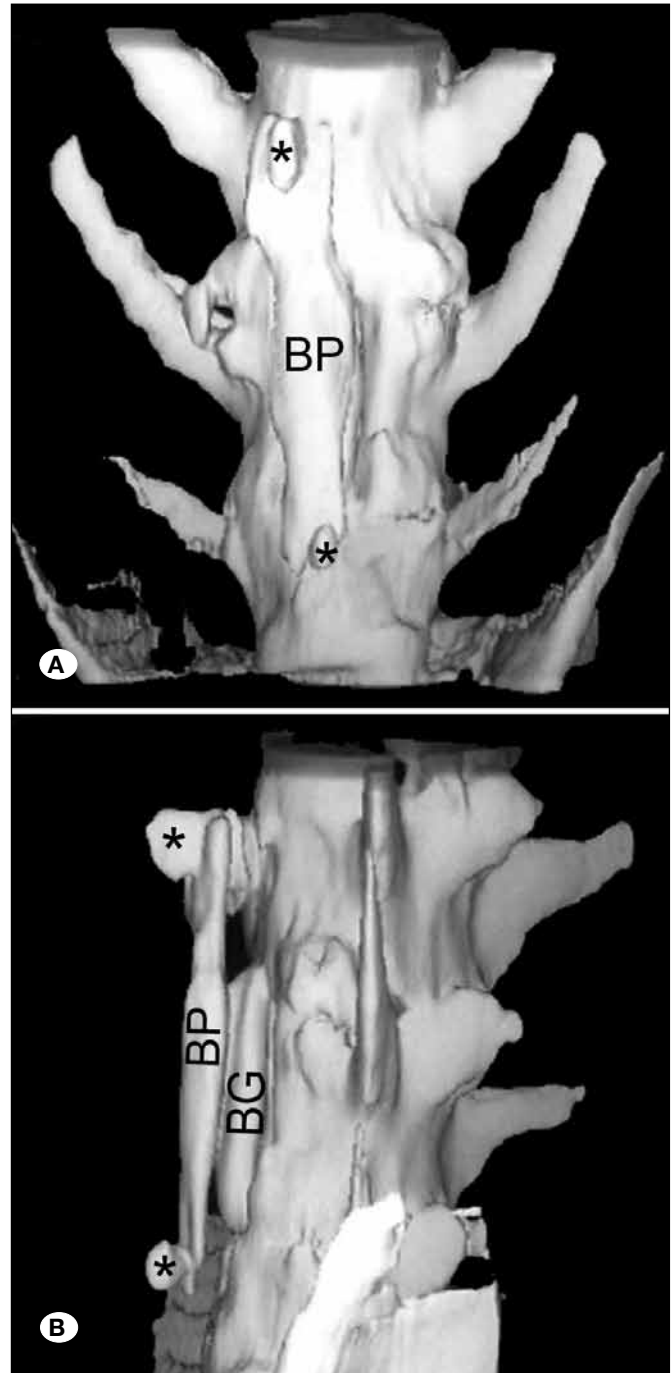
3D computed tomography. A) Front view of fixation area of EG-1 BP; bone plate, Black asterisk; bone screw. B) Side view of fixation area of EG-1, BP; bone plate, BG; bone graft.
